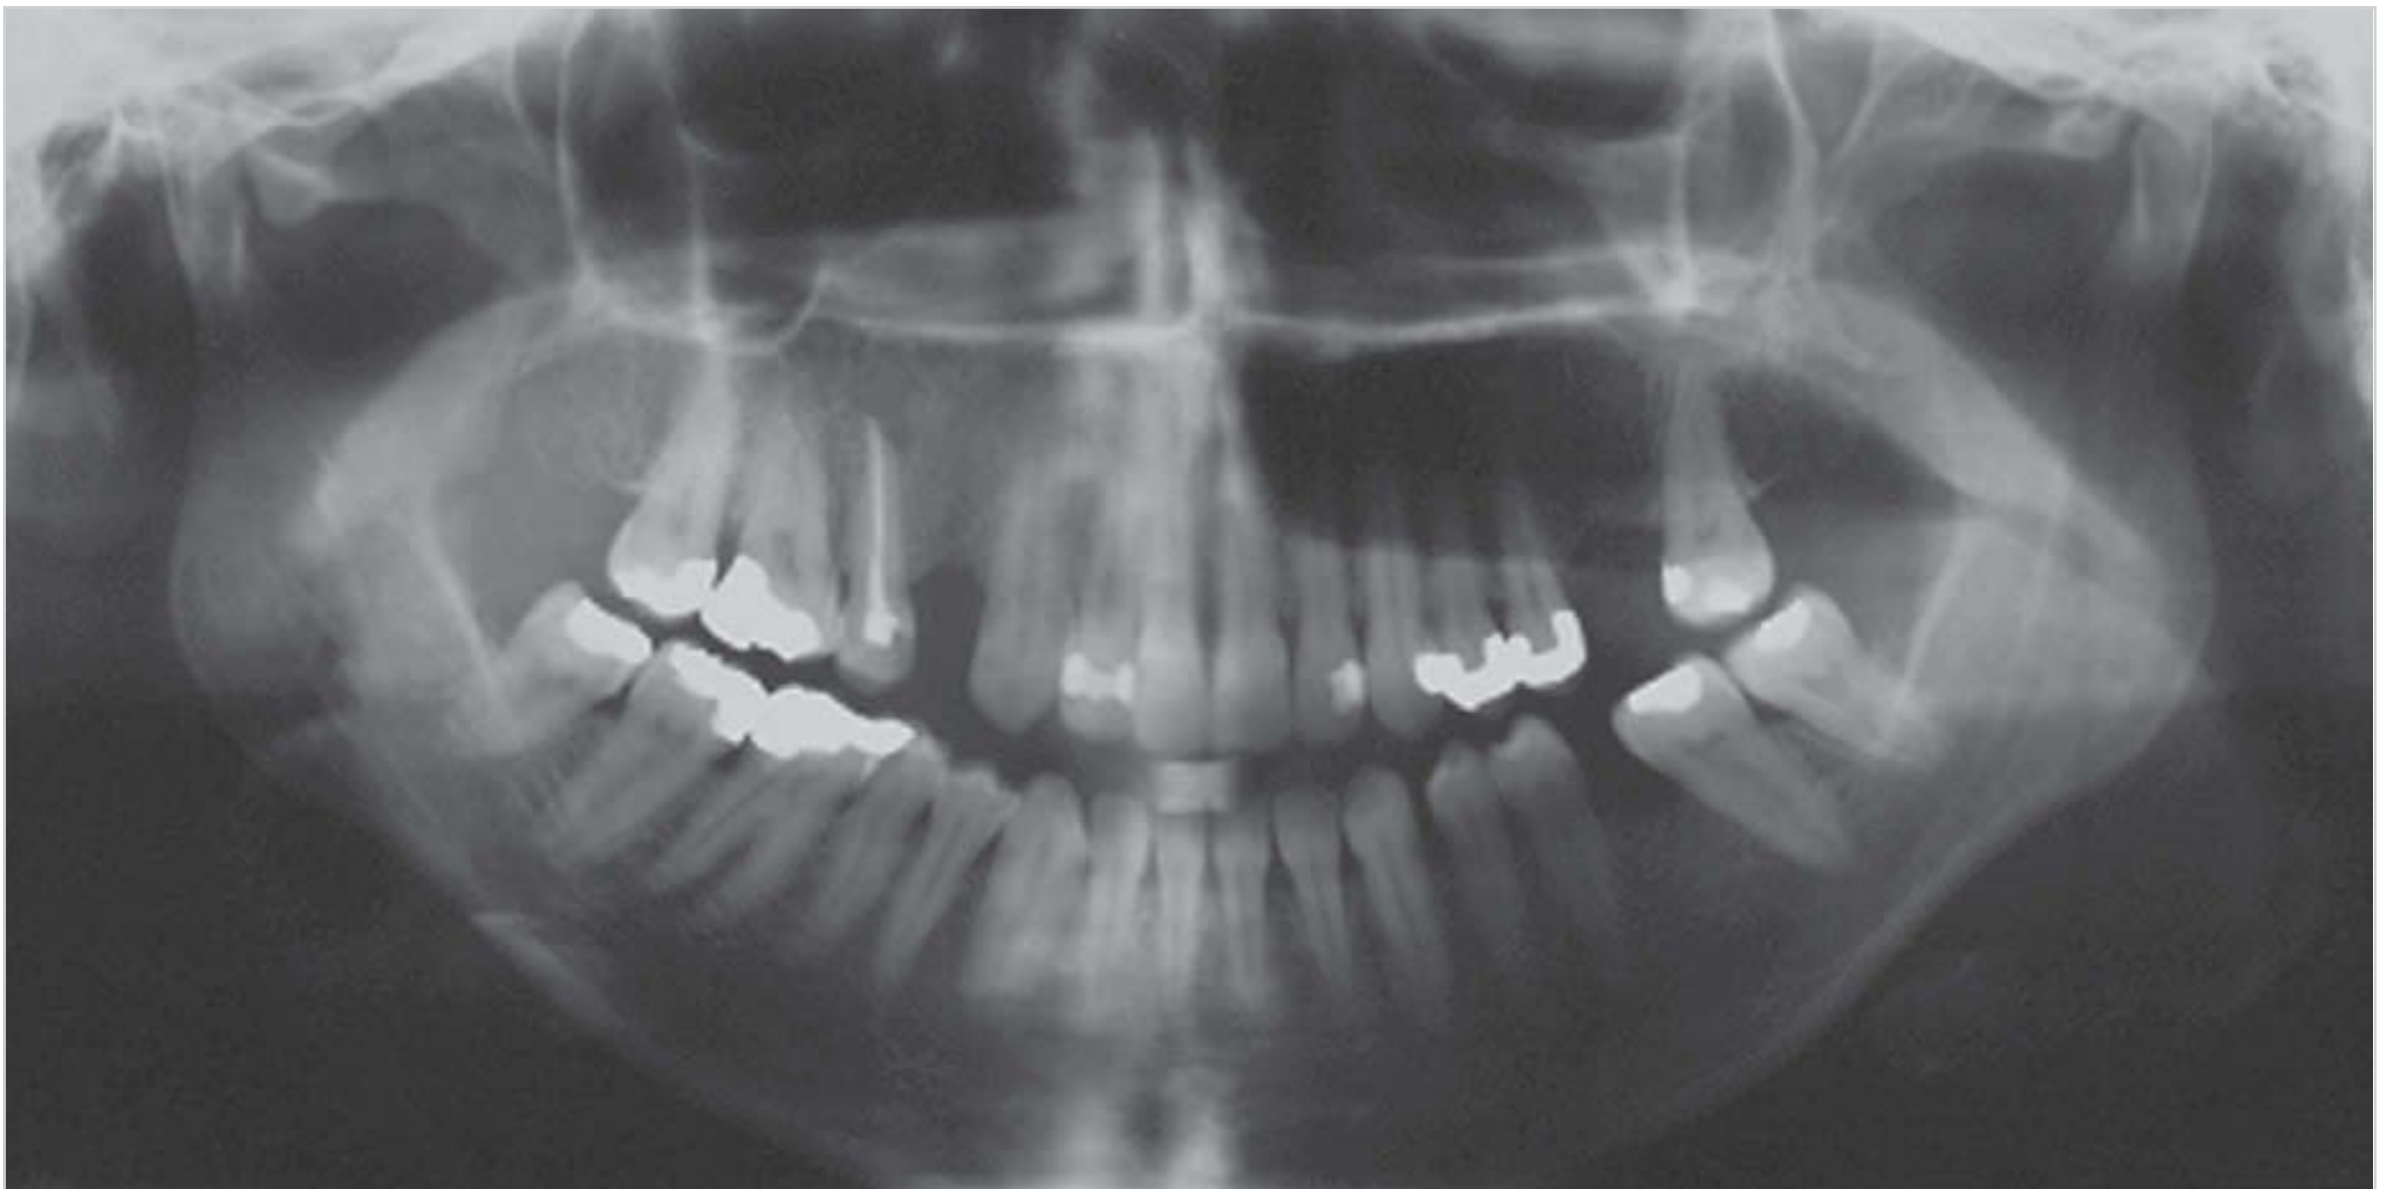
Because the tongue was not positioned against the roof of the mouth at the beginning of the exposure, a black stripe appeared in the left maxillary region of the panoramic radiograph. Later, when the beam scanned the right maxillary region, the tongue was properly positioned against the hard palate.
